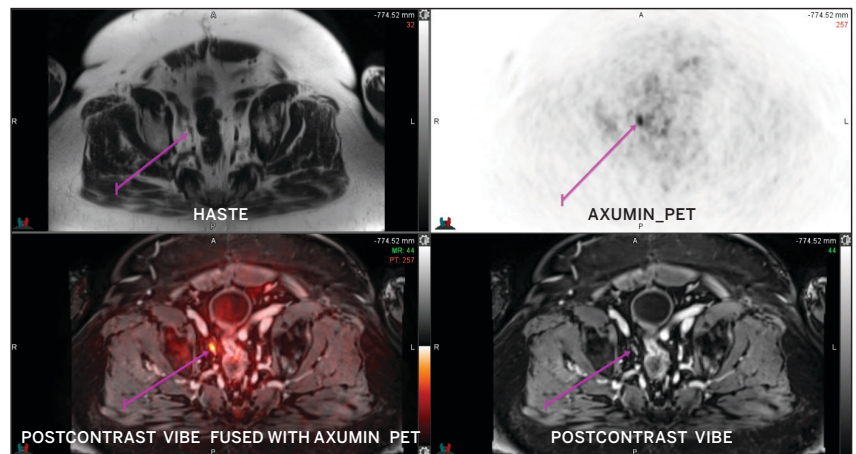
18F-fluciclovine (Axumin) positron emission tomography(PET)/MRI.
